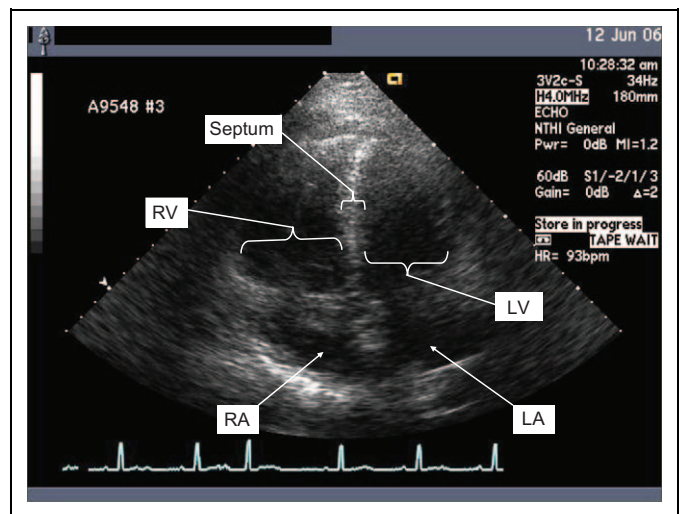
Transthoracic echocardiogram (TTE) with 4 chambers visualized demonstrates RV enlargement and flattening of interventricular septum in a patient with PE. RV indicates right ventricle; AV, atrioventricular; RA, right atrium; LV, left ventricle; LA, left atrium.
